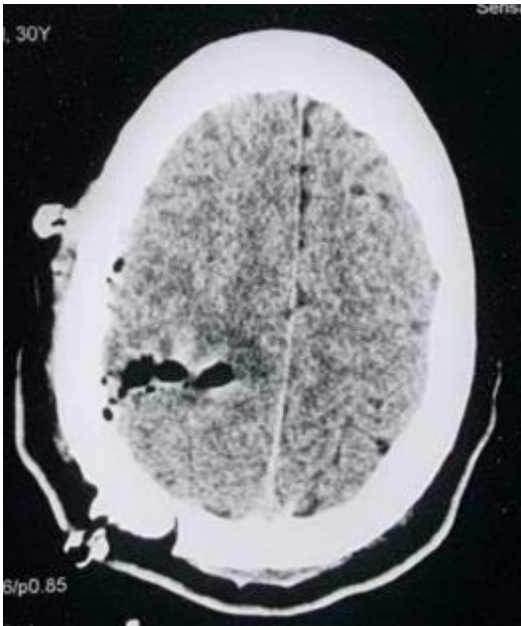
Postoperative axial CT scan, showing the complete resection of the cavernoma
